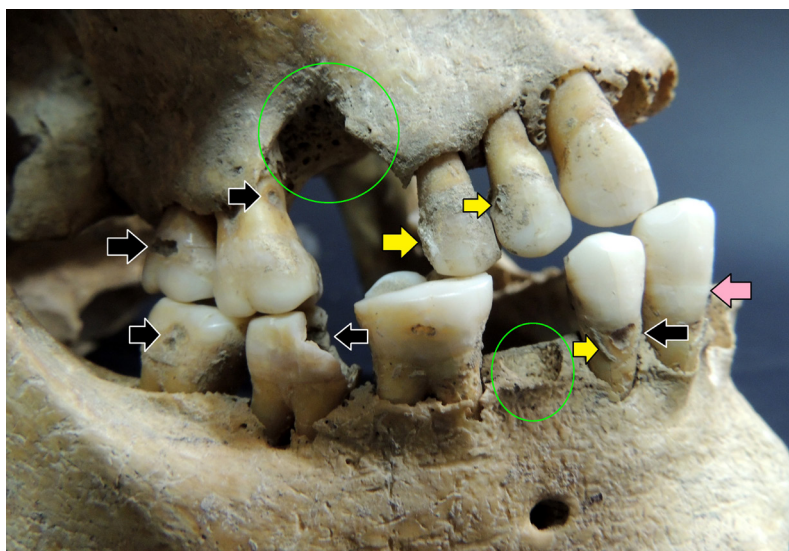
Poor dental health of individual G4-15 with many pathologies: *antemortem* tooth loss (green circle), caries (black arrows), calculus deposits (yellow arrows), lines of enamel hypoplasia (pink arrow) and periapical abscess
